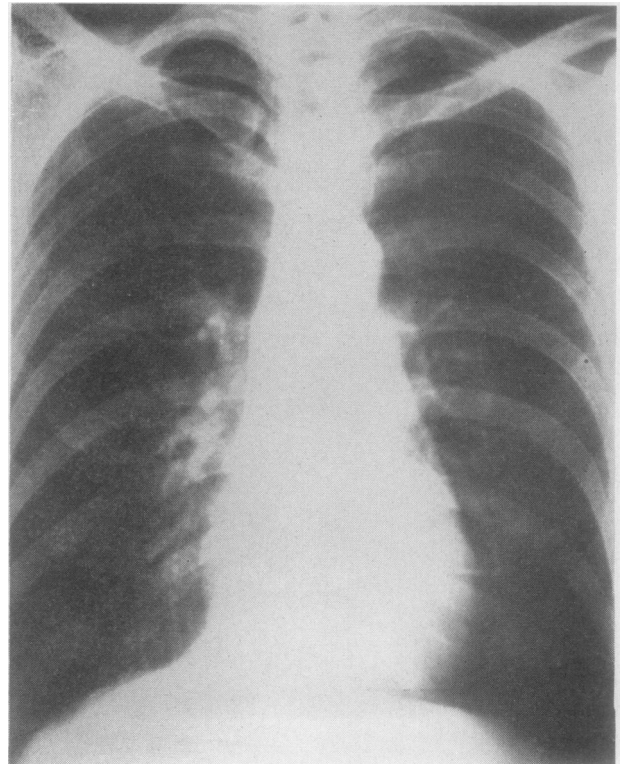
Case 1. Radiograph taken 14 November 1964 shows that complete radiological regression is still maintained 14 months later.*
